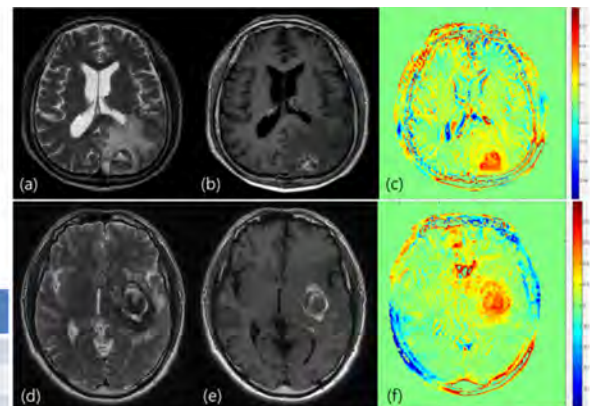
MR images of metastasis (upper row) and cavernous malformation (lower row). T2WI (a) shows cystic lesion with fluid-fluid level due to internal hemorrhage and contrast-enhanced T1WI shows irregular peripheral enhancement. Corresponding MTR asymmetry map (c) demonstrates high signal within the hemorrhage as well as in the enhancing portion. T2WI (d) and T1WI (e) show multiloculated cystic lesion with hemorrhage of mixed stages, suggestive of cavernous malformation. MTR asymmetry is also elevated (f).
